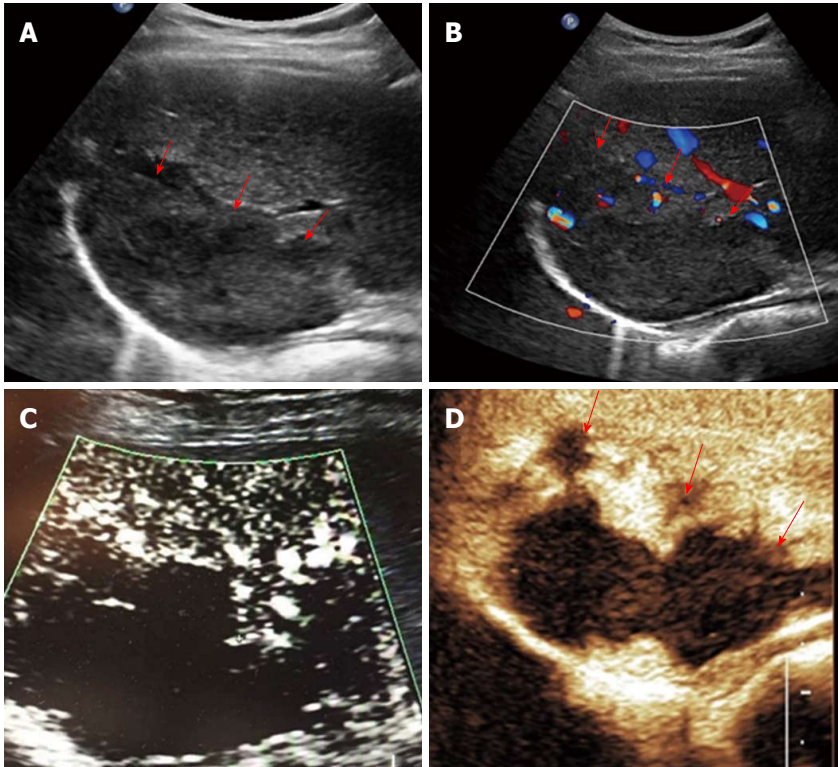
Nodular rim type (type III) in a 51-year-old female diagnosed with hemangioma. A: A mixed-echo lesion with a relatively clear margin was evident in the right liver lobe; B: CDFI showed a sporadic short strip blood flow signal around the edge of this lesion; C: SMI showed a nodular rim-distributed microvascular structure; D: Contrast-enhanced ultrasound showed nodular rim enhancement of the lesion in the arterial phase. SMI: Superb microvascular imaging.
